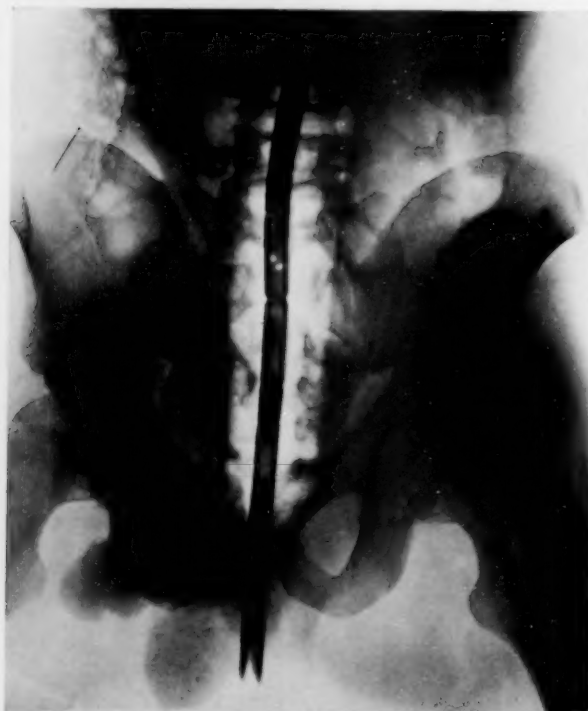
X-ray photograph of dilating apparatus in position in the recto-sigmoid region. The light shadow indicates the outline of the distended bag.
